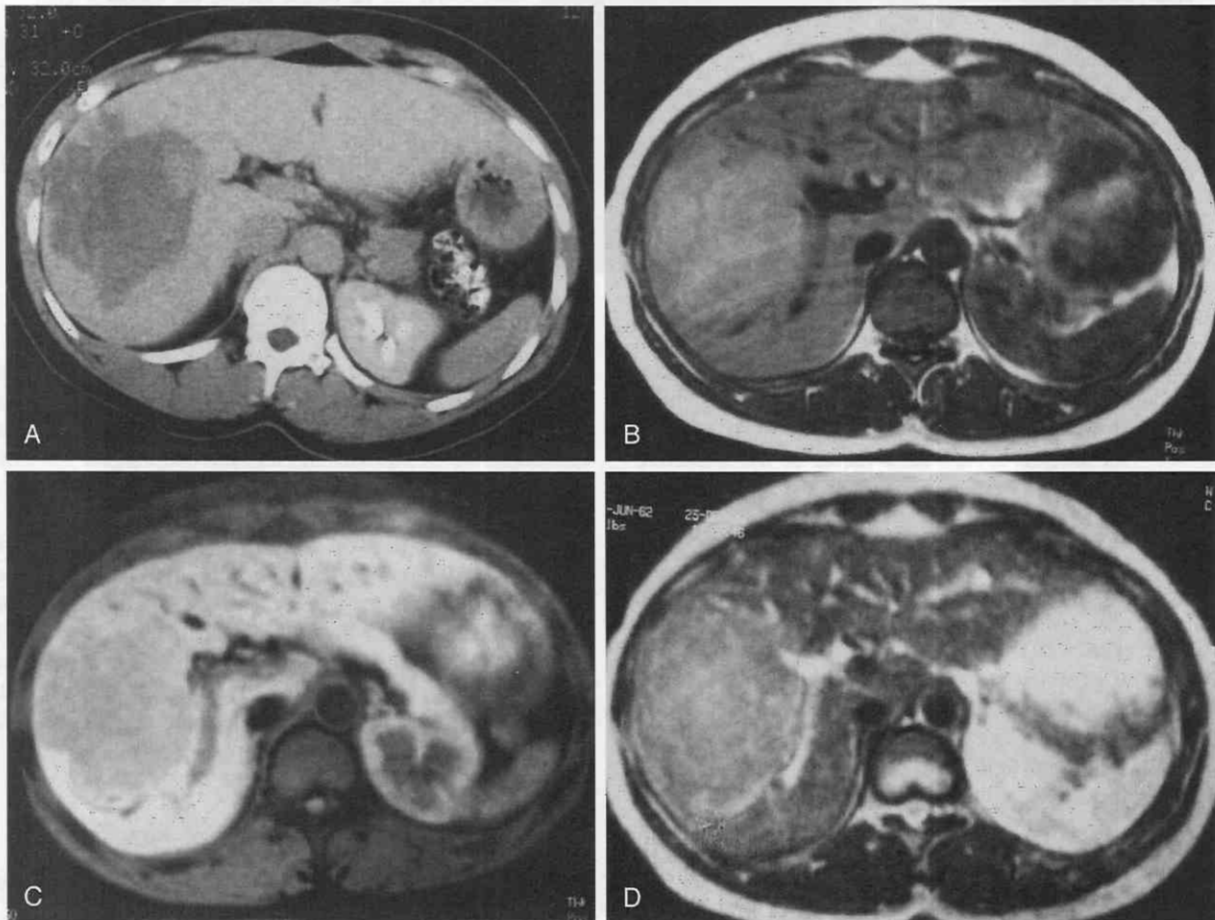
Hepatocellular adenoma in a 29-year-old woman. A, Contrast-enhanced CT scan demonstrates a large mass of mixed attenuation in the right hepatic lobe. B, T1-weighted image (TR = 450 msec, TE = 15 msec) shows the mass to have slightly increased signal intensity relative to the liver. C, Fat-suppression T1-weighted image (TR = 550 msec, TE = 15 msec) now shows the lesion to be lower in signal intensity relative to the liver. This indicates that the mass has a fatty composition. D, T2-weighted image (TR = 2000 msec, TE = 90 msec) shows the mass to be slightly hyperintense relative to the liver.
